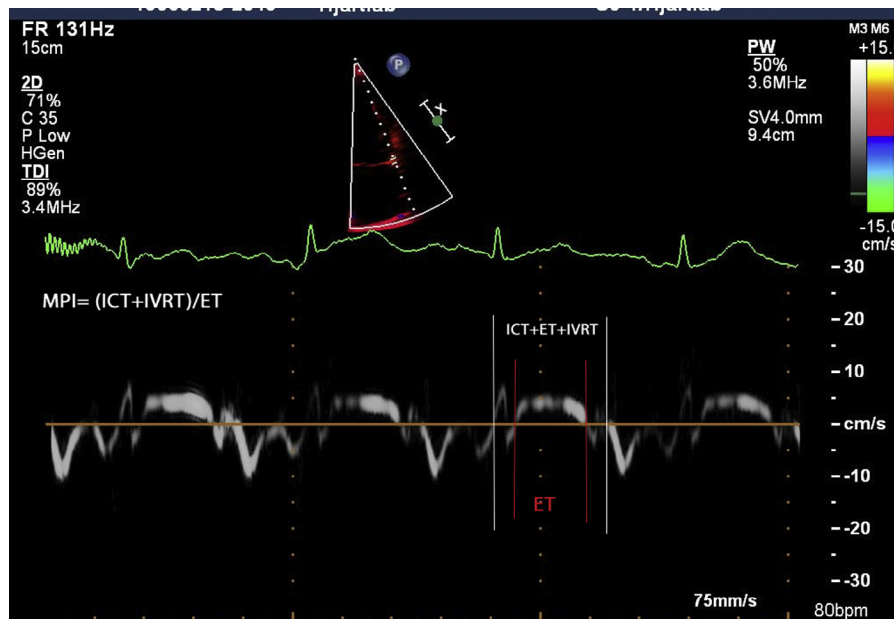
Pulsed-wave tissue Doppler recording from an apical 4-chamber view. MPI, myocardial performance index; ICT, isovolumic contraction time; ET, ejection time; IVRT, isovolumic relaxation time.
